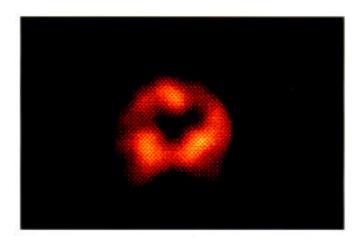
Brain SPECT scan anterior coronal view shows hypoperfusion in the right frontal cortex.
